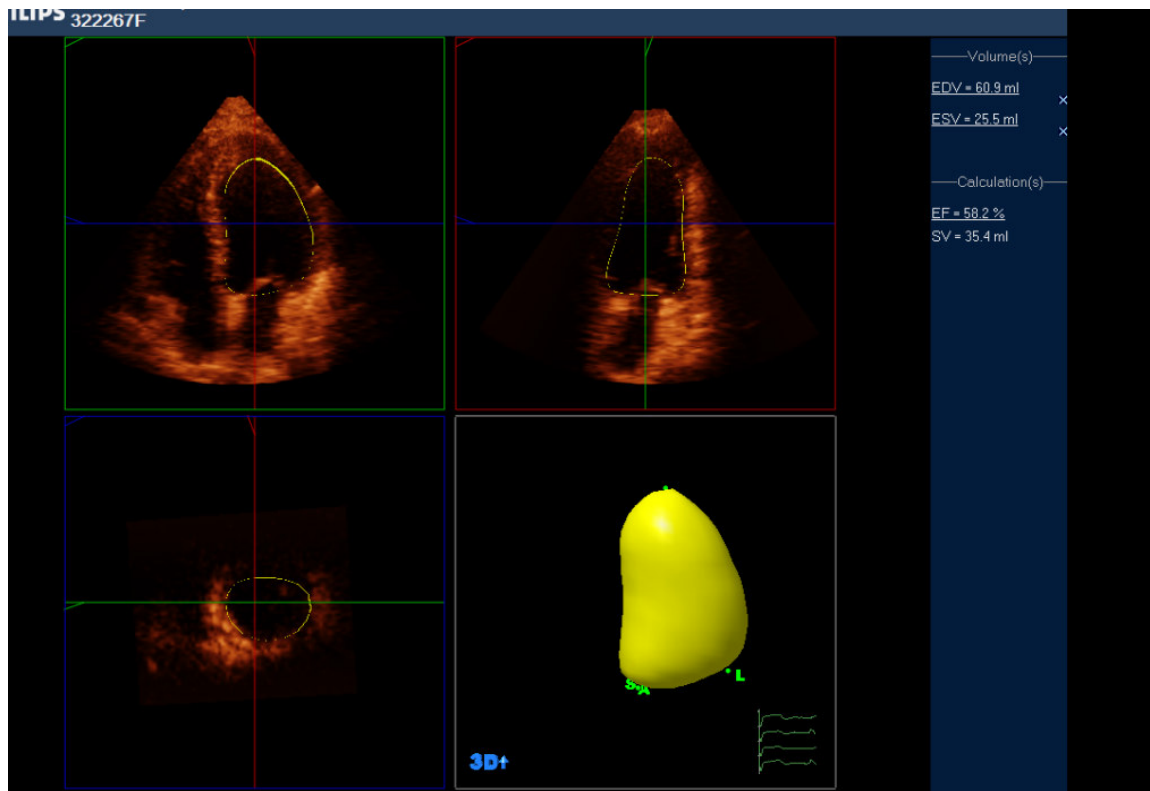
Measurement of 3D EF in echocardiography through Q lab analysis
